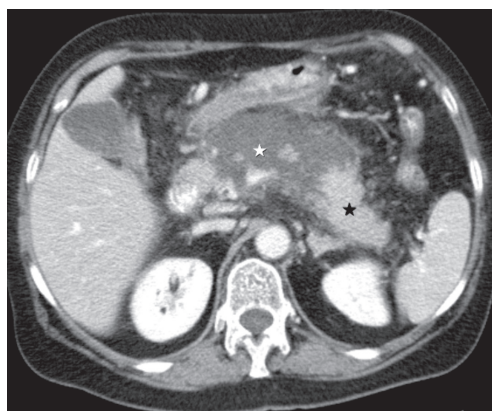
Acute necrotising pancreatitis. Axial contrast-enhanced CT scan in a 45-year-old woman with acute biliary pancreatitis. There is non-enhancement of the neck and part of the body of the pancreas (white asterisk) indicative of parenchymal necrosis with normal enhancement of the tail of the pancreas (black asterisk).
